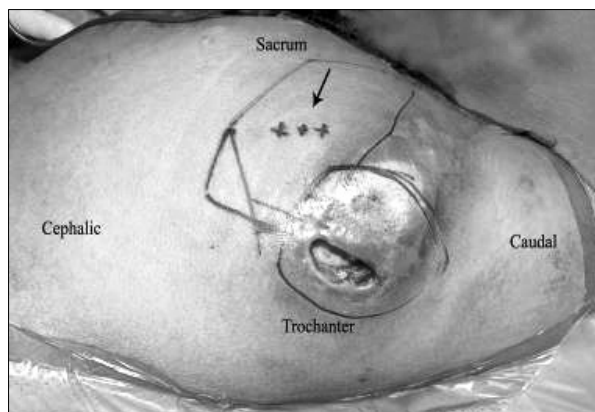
Design of the flap (Patient 3). In the posterior aspect of the lesion, 1-3 gluteal artery perforators close to the lesion were marked with a unidirectional Doppler probe (8 MHz, ES-1000 spm Smartdop[®]), and a transposition flap containing the perforators was designed considering primary closure of the donor site (arrow-marked location of perforators).
